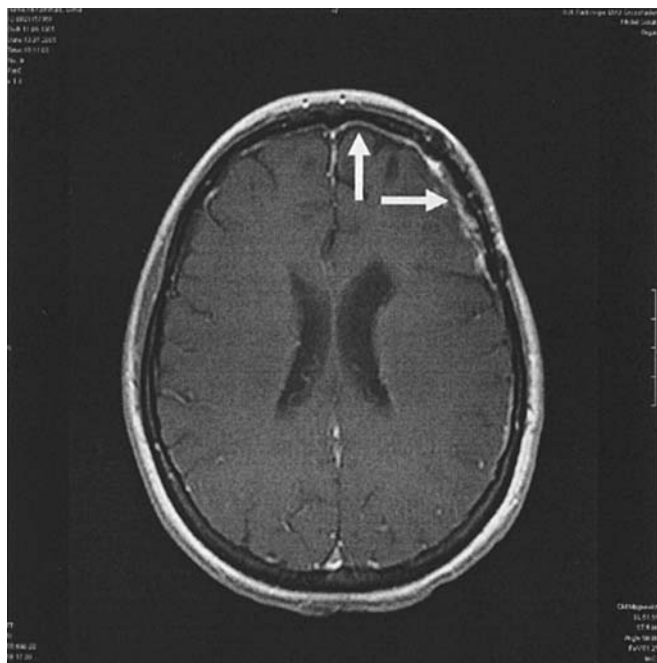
MRI post contrast scan: meningeal enhancement leading to the diagnosis of meningeal carcinomatosis (January 2005). Arrows indicate meningeal enhancement.
